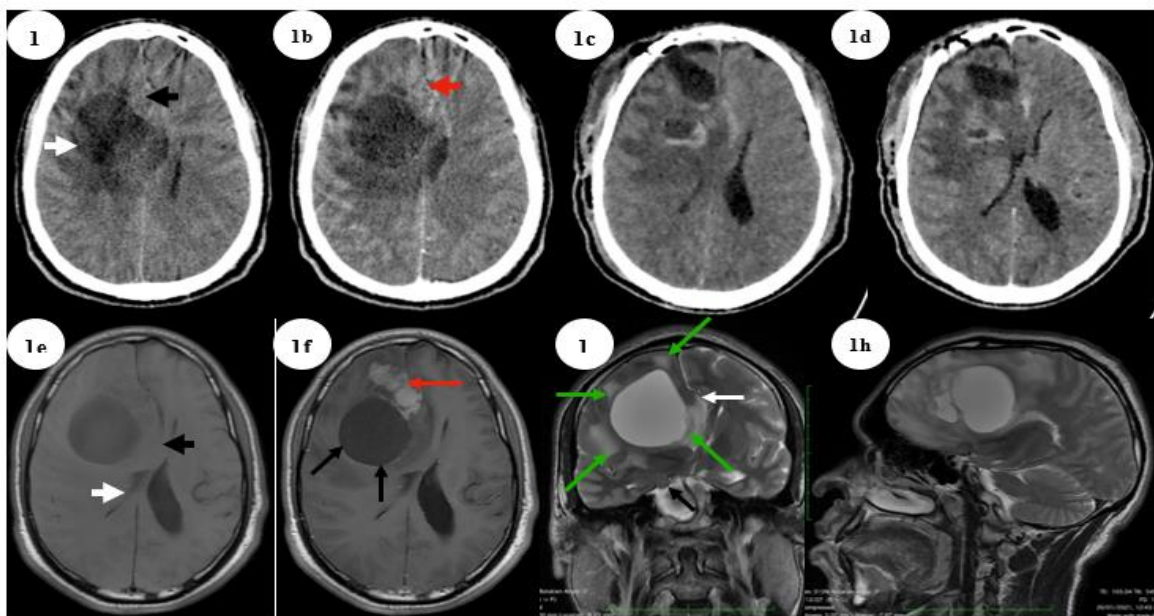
(a-d): Cranial computerised tomography (CT) scan (Pre/post-operative).
